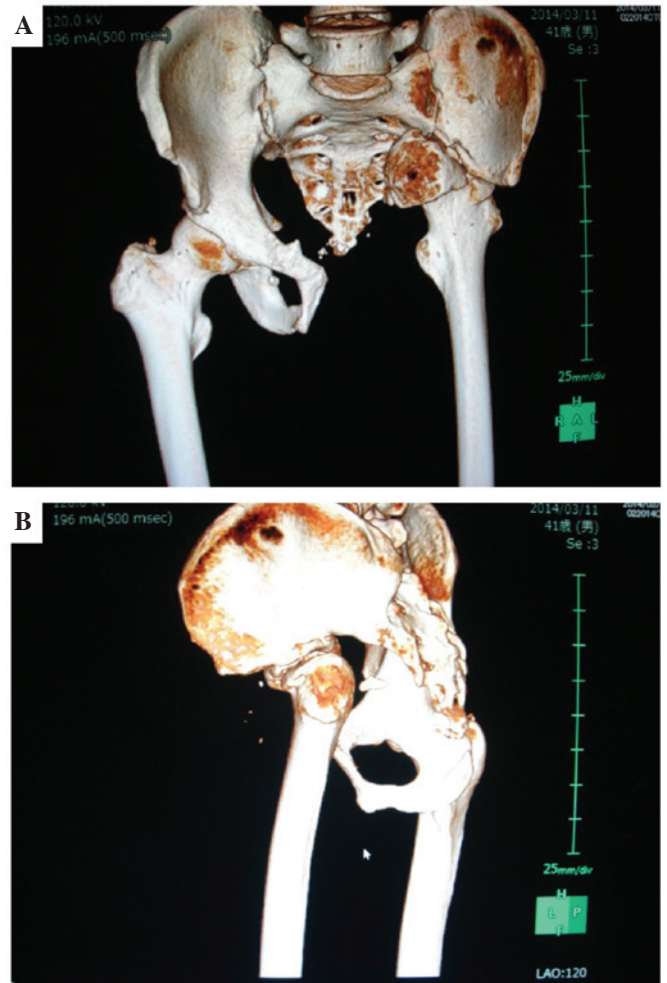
Three-dimensional computed tomography scan demonstrating the association between the femoral neck and the remaining ilium in the (A) anterior and (B) lateral view.
